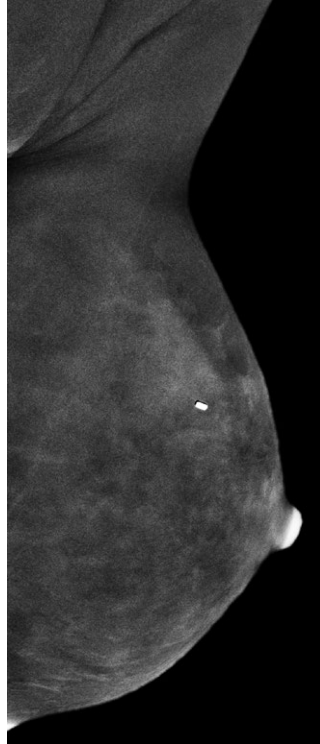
BACKGROUND PARENCHYMAL ENHANCEMENT: ASYMMETRIC. Minimal BPE right breast, moderate BPE left breast in a patient with a history of right breast cancer status post breast—conservation surgery and radiation therapy. Marker clip on the left from remote ultrasound-guided biopsy of a 7 mm mass yielding fibroadenoma. Left MLO recombined image.
